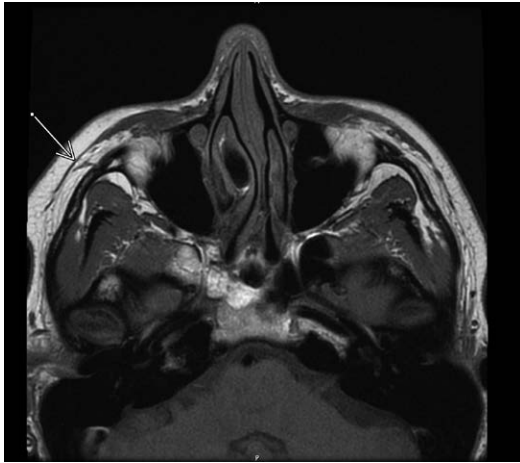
Axial T1-weighted sequence 3-T magnetic resonance imaging scan obtained using the GE Pioneer. *Arrow* indicates the superficial musculoaponeurotic system.
